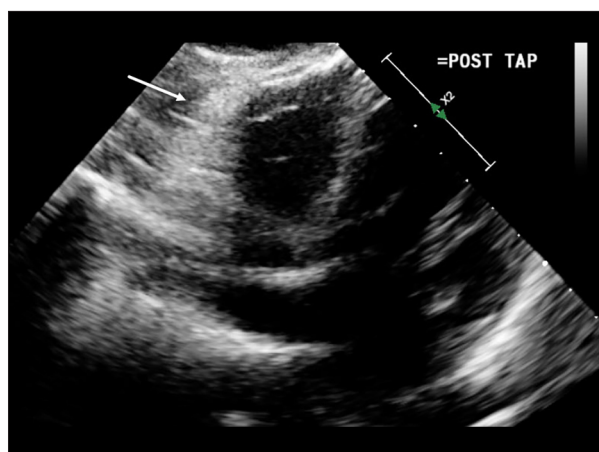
Follow-up transthoracic echocardiography after pericardiocentesis demonstrating resolution of the pericardial effusion and normalization of cardiac chamber filling. Arrow indicates the now-decompressed pericardial space.
